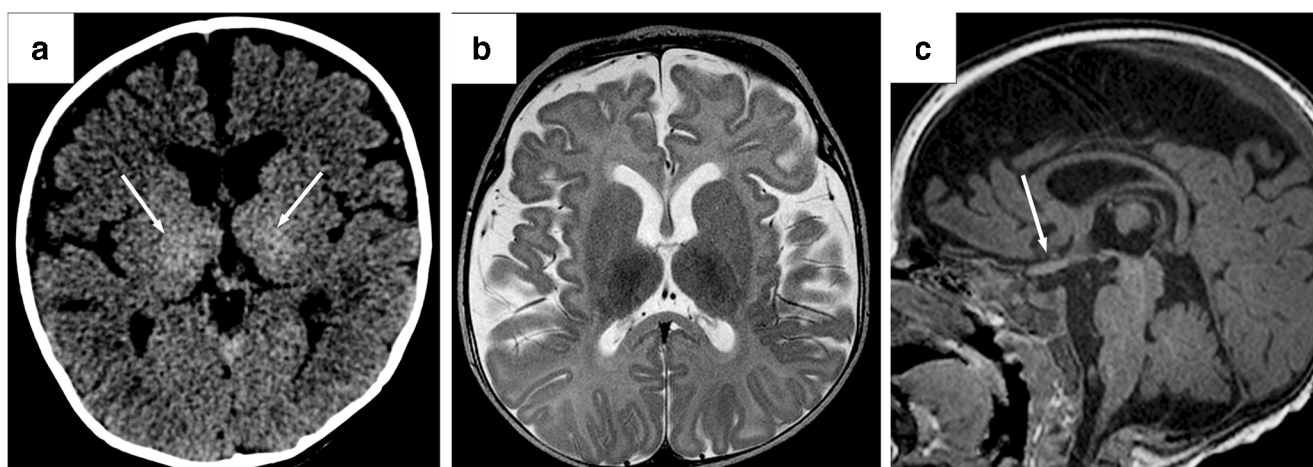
Krabbe disease in a 2-year-old girl with developmental delay, dystonia and epilepsy. a Nonenhanced CT axial image shows subtle bilaterally increased density in the bilateral thalami (arrows). b Axial T2-weighted MR image shows mild prominence of the cerebrospinal fluid spaces, more so along bilateral frontal and temporal regions, mild
